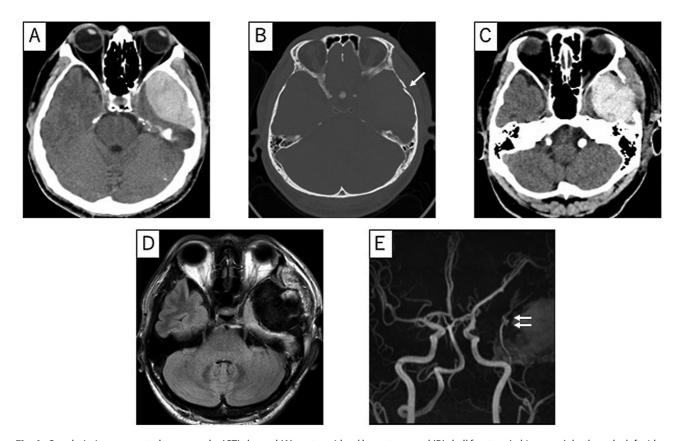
On admission, computed tomography (CT) showed (A) acute epidural hematoma and (B) skull fracture (*white arrow*), both on the left side. (C) CT on the next day after surgery showed hematoma recurrence. Seven days after injury, (D) a fluid-attenuated inversion recovery magnetic resonance (MR) imaging showed no hematoma enlargement, and (E) MR angiography showed an aneurysm of the left middle meningeal artery (*two white arrows*).
